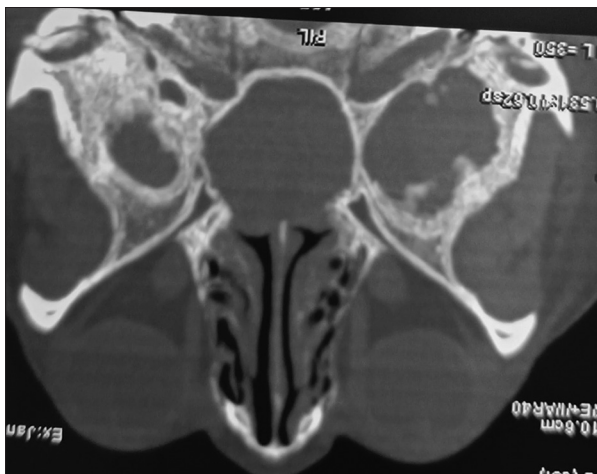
Computed tomography scan of the nose and paranasal sinus (axial view) showing sphenoid sinus mucocele
